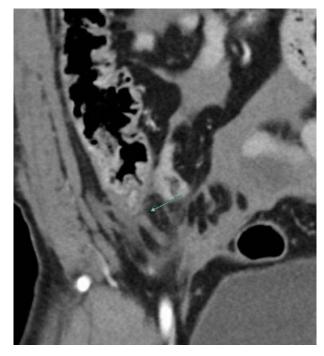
Showing the transected appendix in the CT scan
